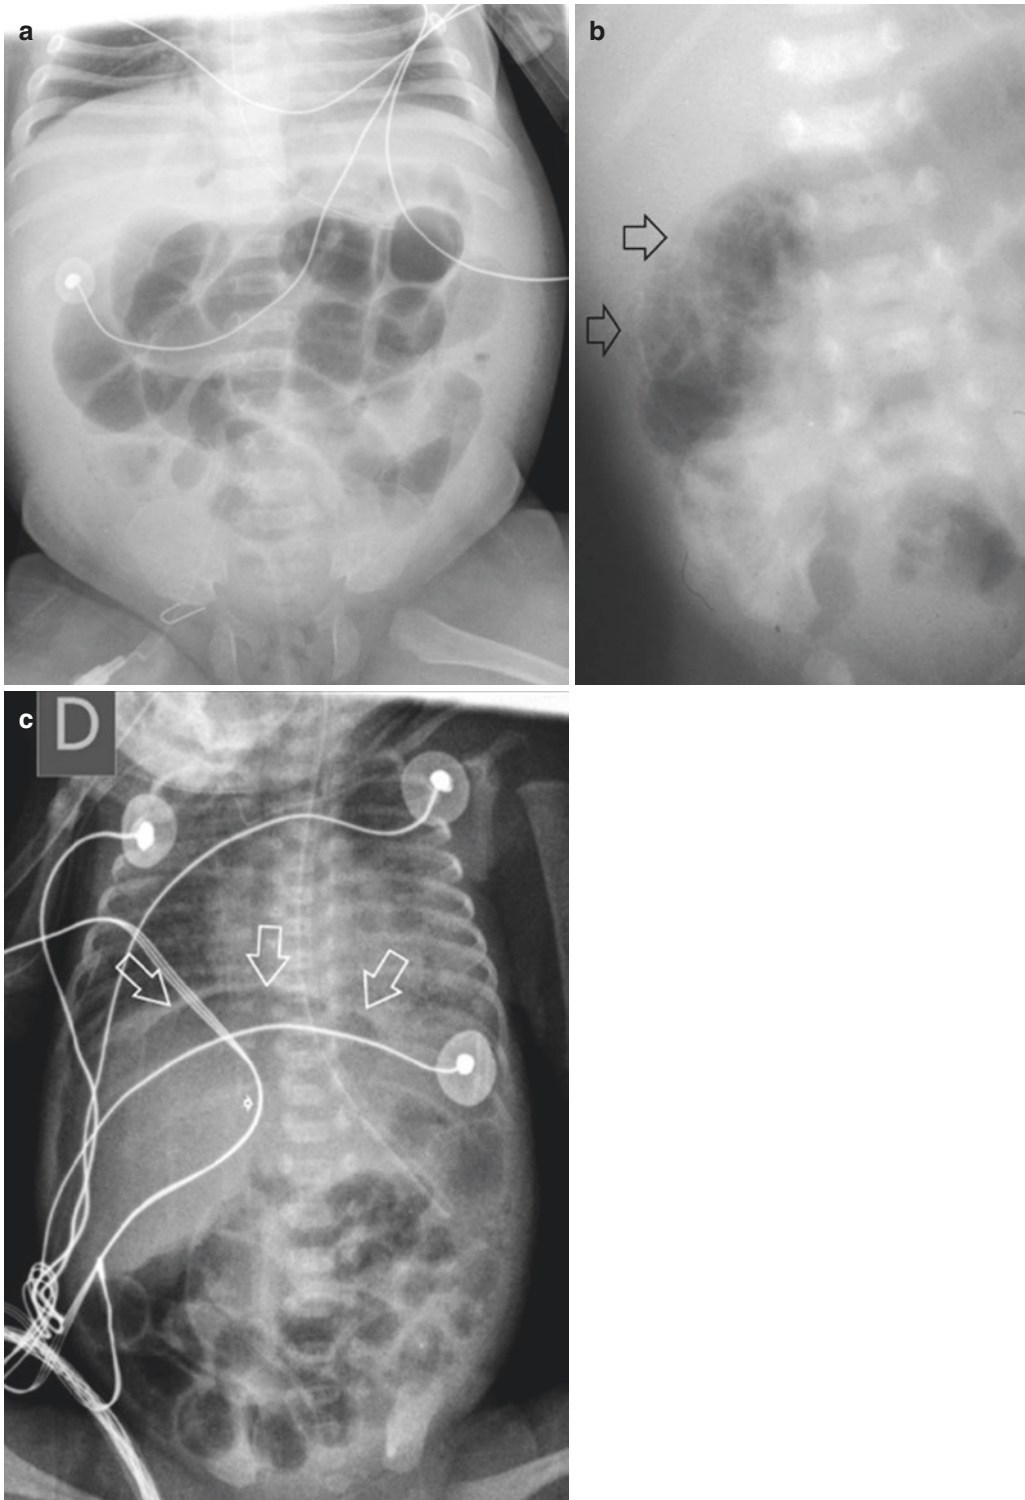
NEC—Various stages on plain abdominal radiograph. (a) Stage 1. Plain radiograph of the abdomen showing distended bowel loops. The distance between some bowel loops is increased suggesting bowel wall thickening and/or effusion. (b) Stage 2. Focused plain radiograph
